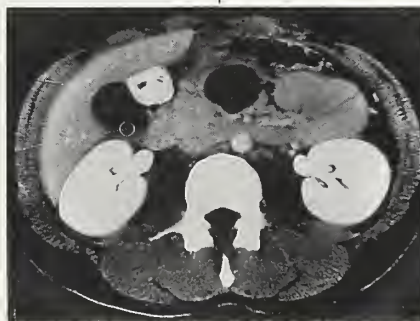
CT scan of the abdomen done eight days after admission showing partial resolution of the pancreatic phlegmon and development of a pseudocyst.
